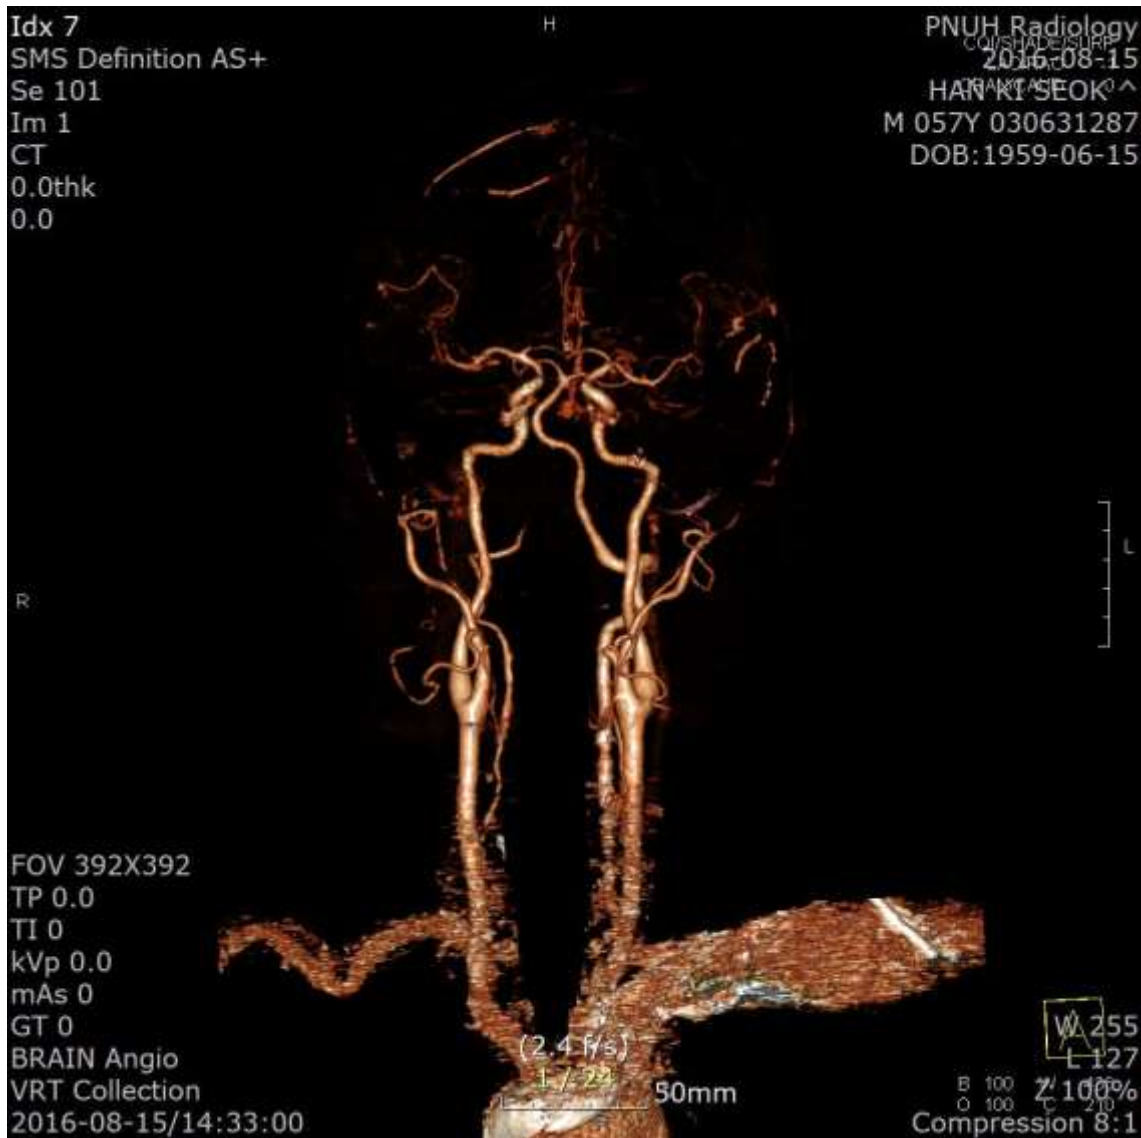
Brain computed tomography angiography showing left anterior cerebral artery aneurysm rupture.
